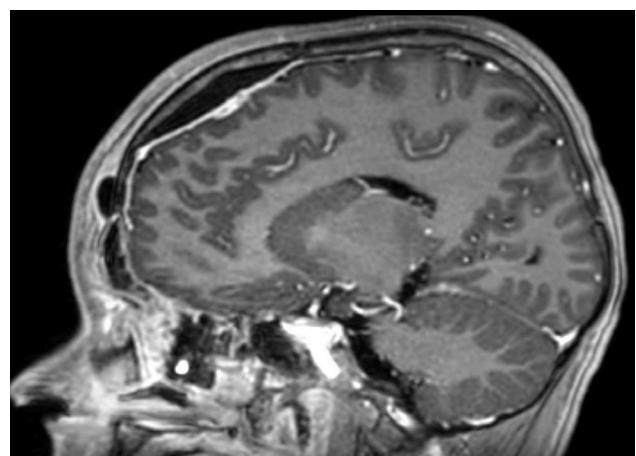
Magnetic resonance imaging shows complete remission of extradural abscess (sagittal image).
